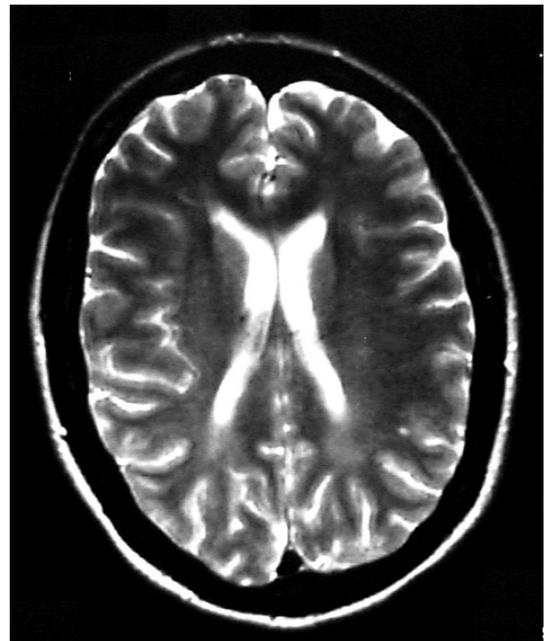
MRI scan of the brain showing some of the components of the lateral ventricles
